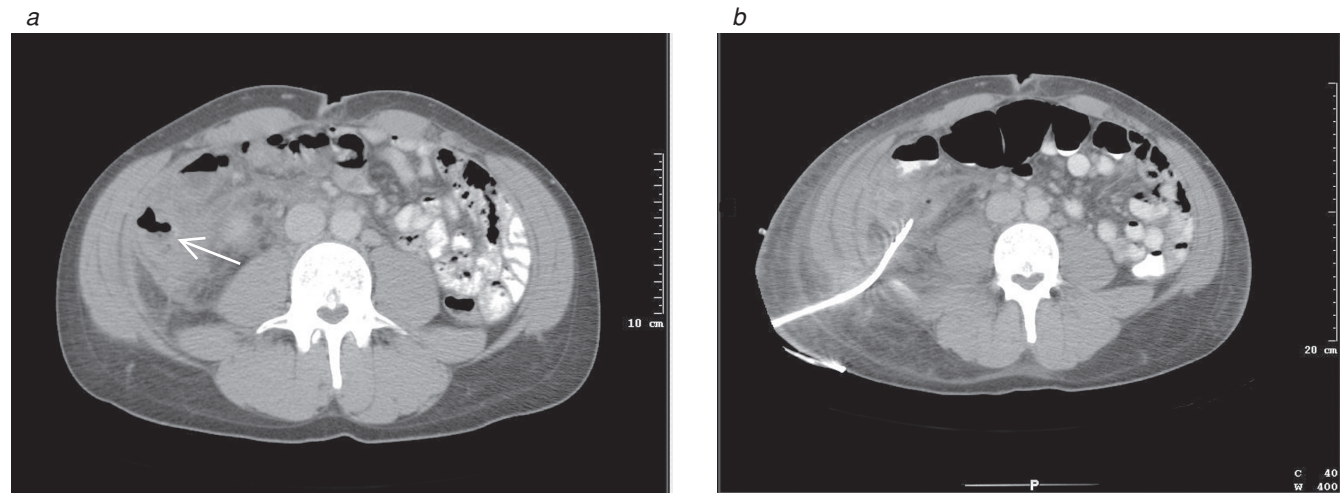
(a) A pelvic computed tomographic (CT) scan of a young patient with a 5-day history of right lower quadrant abdominal pain showing fluid collection containing air adjacent to the appendix and consistent with appendiceal perforation and abscess formation (*white arrow*). (b) A pelvic CT scan of the same patient after percutaneous ultrasound-guided placement of drainage catheter showing evacuation of air and much fluid. The patient underwent uneventful interval appendectomy 6 weeks later.
